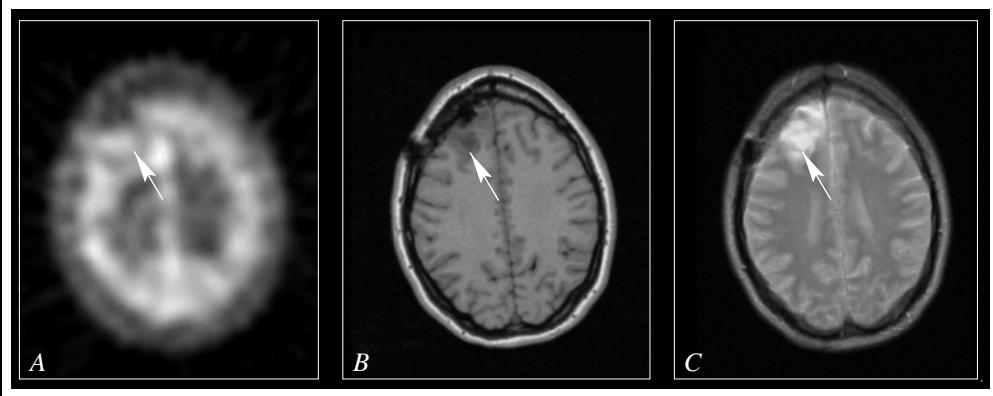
Adjacent display with a linked cursor: Corresponding slices from the original images of three modalities. (A) SPECT image, (B) MR-T1 image, (C) MR-T2 image.
